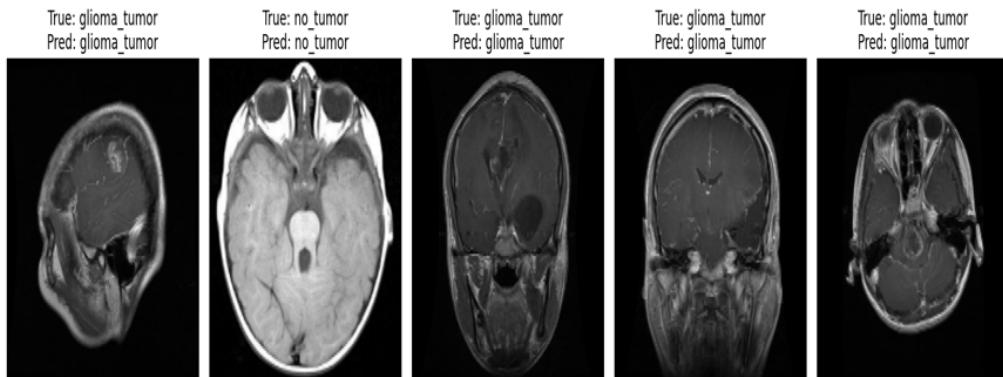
MRI Sample Predictions
